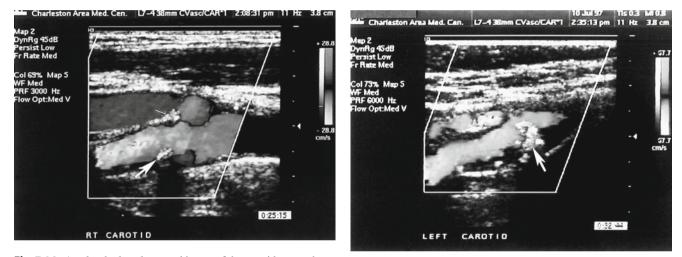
A color duplex ultrasound image of the carotid artery showing a calcified plaque (*arrow*) with acoustic shadowing underneath (*under the arrow*)
